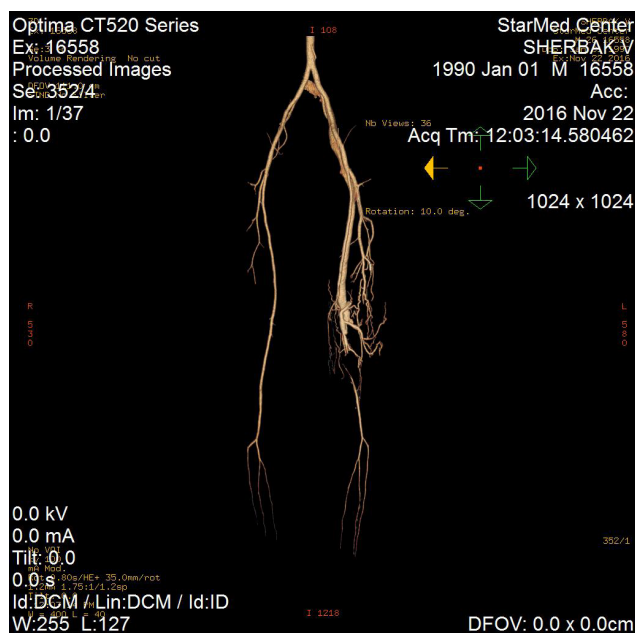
Postoperative recurrence of TAVS superficial femoral artery and vein, left. 5 patients with TAVS showed signs of venous insufficiency. It is a clearing of the skin of the saphenous veins. 3 patients had a pulsation in this area. During auscultation of the TAVS area, systolic murmur was heard in 5 patients, diastole – systolic murmur and tremor in 28 patients (90.3%). Thus, it was 11; till 2 o'clock – 11; from 3–6,5 hours and more to 8 patients. Important diagnostic methods for TAVS are: radiological; Ultrasound 11; USDG-6; angiography- 15; MSCT-10; duplex research-1
